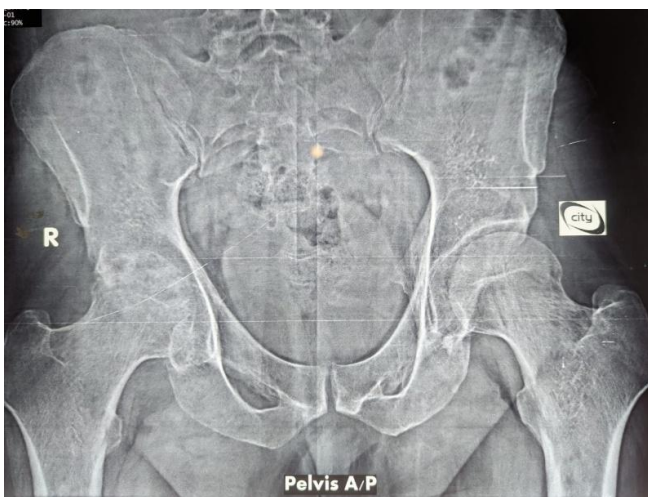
Pre-operative Anteroposterior (AP) radiograph
